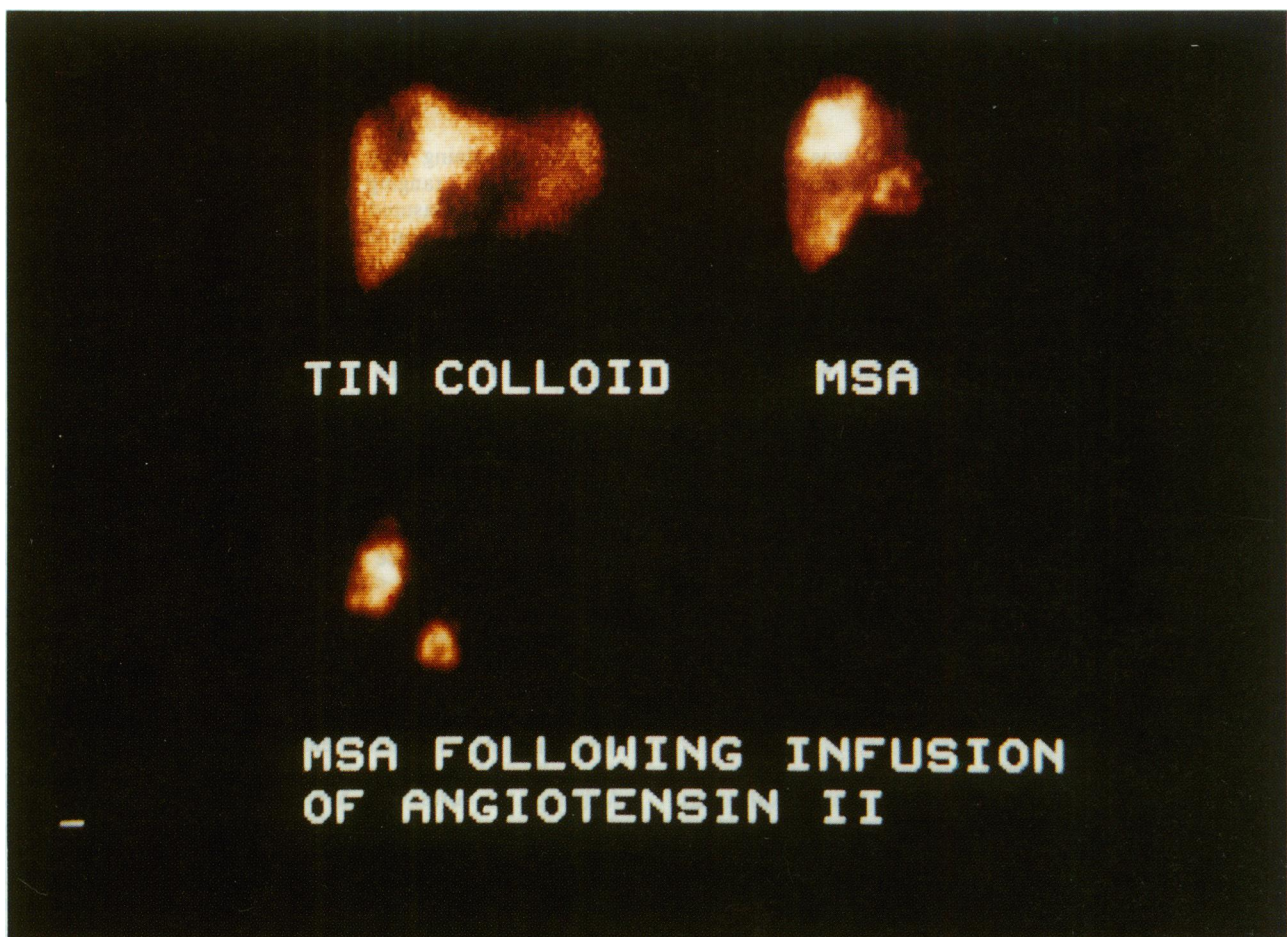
Anterior planar views of three studies in one patient: (i) Albumin colloid. (Top left). (ii) Hepatic arterial perfusion scintigraphy. (Top right). (iii) Angiotensin II enhanced hepatic arterial perfusion scintigraphy. (Bottom).
